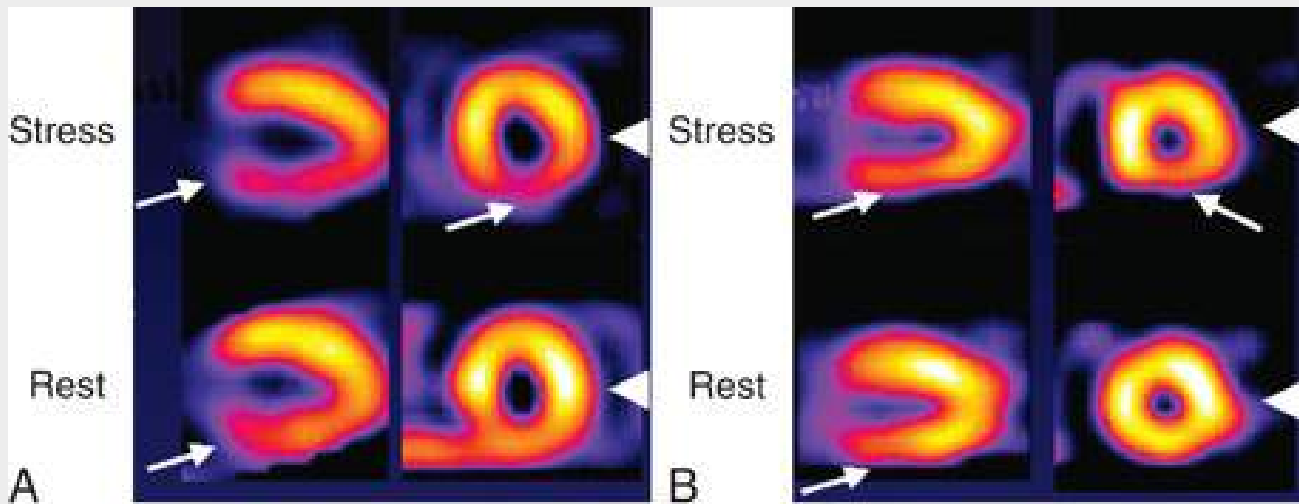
SPECT images of inferior wall abnormalities of differing extent and severity. A, Large, moderately severe, reversible inferior wall defect (*arrows*) reflecting a moderately severe flow reserve abnormality. B, Milder, reversible inferior wall defect (*arrows*) reflecting either a less severe stenosis or a severe stenosis with well-developed collaterals minimizing the defect severity. In both patients, a mild lateral wall reversible defect also is present (*arrowheads*). Note how the lateral wall brightens relative to the septum on the rest images compared with the stress images.
